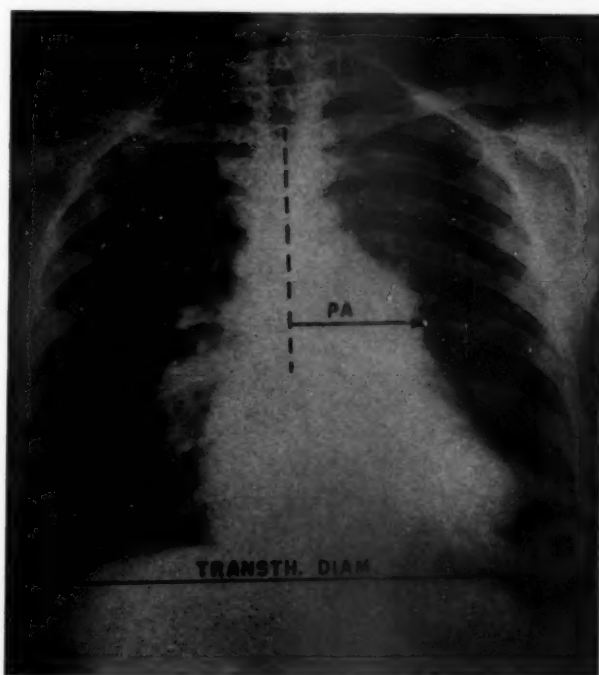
Determination of the pulmonary artery/chest ratio. PA: Size of the pulmonary arterial segment, in centimeters, measured from the midline, as defined by the thoracic spines, to its most prominent point on the left cardiac border. Transth. Diam.: Greatest transthoracic diameter, in centimeters, measured from pleura to pleura.
